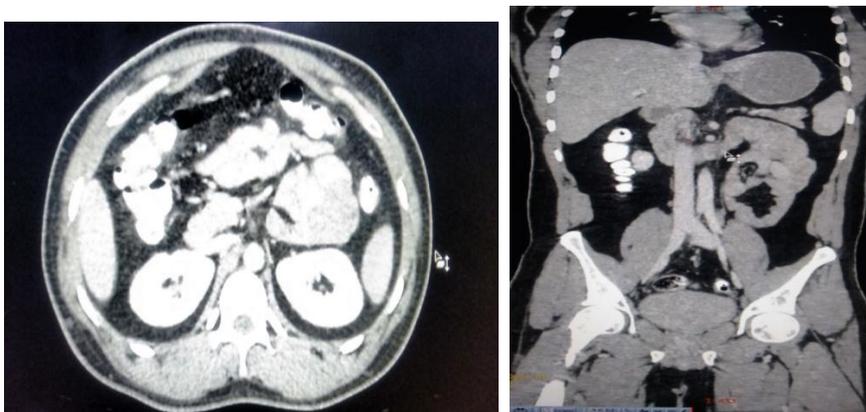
Computed tomographic scan showing incarcerated loops of small bowel in the left paraduodenal area. And enhanced Computed Tomographic picture demonstrates a cluster of small
